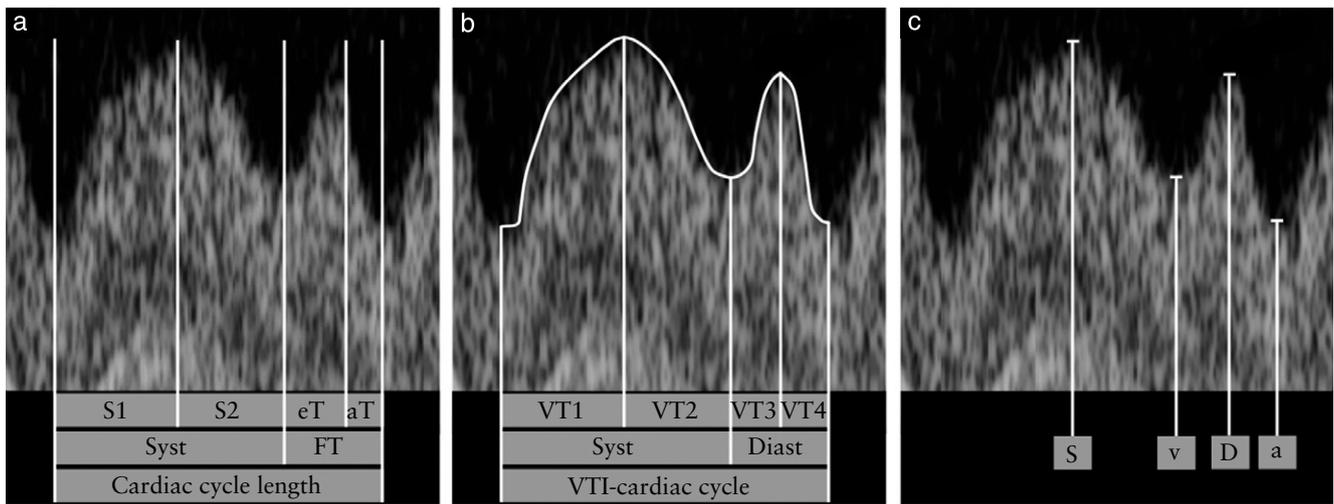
Annotated ductus venosus Doppler waveforms showing acquisition of time intervals, velocity-time integrals (VTIs) and peak velocities. (a) Ductus venosus time intervals. S1, acceleration time during ventricular systole, measured from nadir of a-wave to peak of systole; S2, deceleration time during end-systolic ventricular relaxation, from peak of systole to nadir between systole and diastole; Syst, sum of S1 and S2; eT, early diastolic filling time, from onset of diastolic filling to beginning of fast deceleration caused by atrial contraction; FT, total diastolic filling time, from onset of diastolic filling to nadir during atrial contraction; aT, late diastolic filling time, obtained by subtracting eT from FT. $S1 (\%) = S1 (\text{ms})/\text{cardiac cycle length (ms)}$, $S2 (\%) = S2 (\text{ms})/\text{cardiac cycle length (ms)}$, $eT (\%) = eT (\text{ms})/\text{cardiac cycle length (ms)}$, $aT (\%) = aT (\text{ms})/\text{cardiac cycle length (ms)}$, $FT (\%) = FT (\text{ms})/\text{cardiac cycle length (ms)}$, $\text{syst} (\%) = \text{syst} (\text{ms})/\text{cardiac cycle length (ms)}$. (b) Ductus venosus VTIs. VT1, acceleration during ventricular systole, measured from nadir of a-wave to peak of systole; VT2, deceleration during systole, measured from peak of systole to nadir; Syst, sum of VT1 and VT2; VT3, acceleration during ventricular diastole, measured from nadir of v-wave to peak of diastole; VT4, deceleration during diastole, measured from peak of diastole to nadir of a-wave; Diast, sum of VT3 and VT4. $VT1 (\%) = VT1/\text{VTI-cardiac cycle}$, $VT2 (\%) = VT2/\text{VTI-cardiac cycle}$, $VT3 (\%) = VT3/\text{VTI-cardiac cycle}$, $VT4 (\%) = VT4/\text{VTI-cardiac cycle}$, $VT1\text{-syst} (\%) = \text{syst}/\text{VTI-cardiac cycle}$, $VT1\text{-diast} (\%) = \text{diast}/\text{VTI-cardiac cycle}$. (c) Ductus venosus peak velocities of S-, v-, D- and a-waves.
